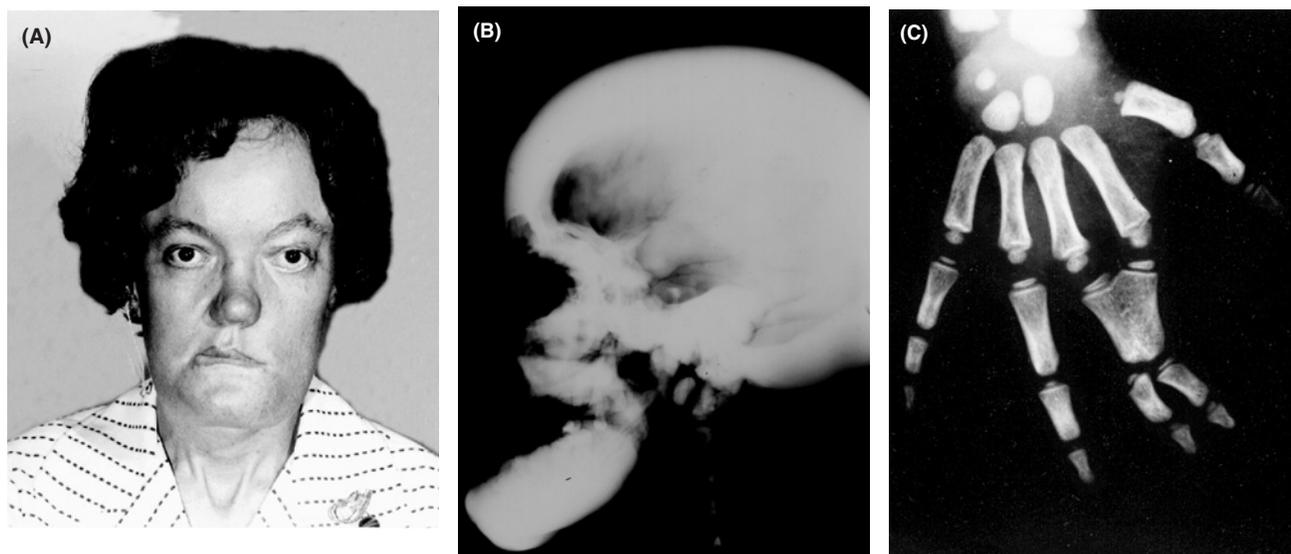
Clinical manifestations of sclerosteosis. (A) Patient with sclerosteosis with characteristic mandibular overgrowth, facial palsy, tall forehead, and deafness. (B) X-ray of the skull of an adult patient with sclerosteosis showing thickening of the skull and mandible. (C) X-ray of the hand of a child with sclerosteosis showing syndactyly of the second and third finger (Reprinted from van Bezooijen *et al.*, SOST/sclerostin, an osteocyte-derived negative regulator of bone formation. *Cytokine & Growth Factor Reviews* 2005 16(3) pp. 319–327 with permission from Elsevier).
